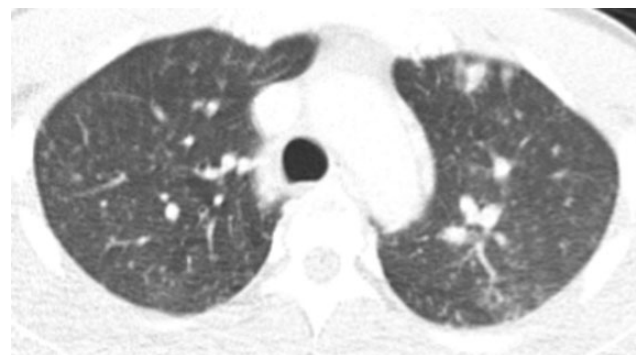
Chest computed tomography with mixed pattern of large and small nodules.
